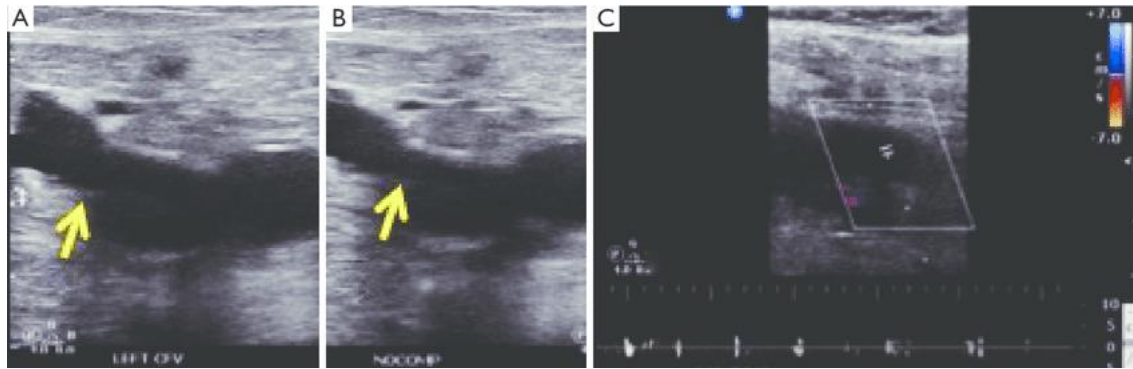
Acute deep vein thrombosis on ultrasound. Available from: (61).
